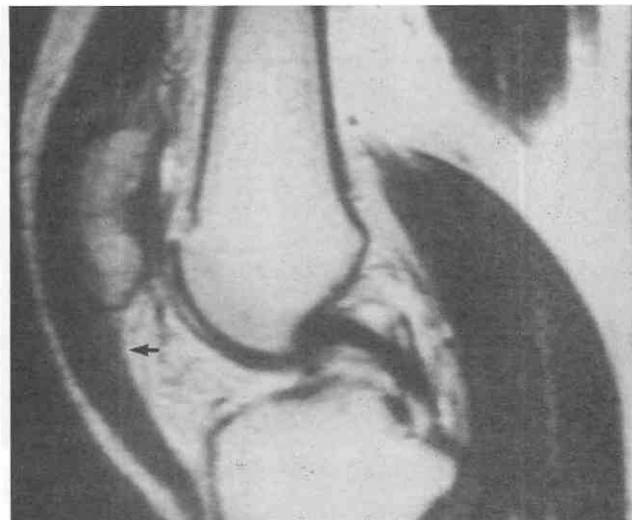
Patellar tendinitis. Sagittal T1-weighted image shows thickening of the patellar ligament proximally (arrow).
